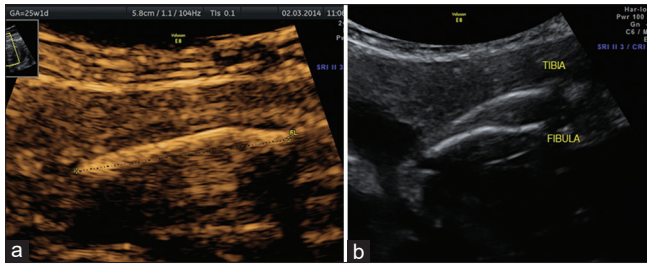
Ultrasound images of the lower limb bones, femur (a) and tibia, and fibula (b) in a fetus with Stuve–Wiedemann syndrome
